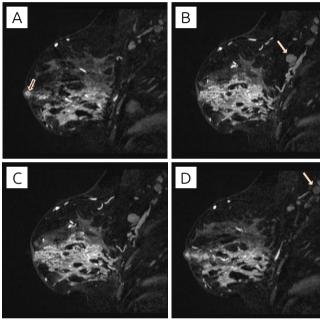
Axial magnetic resonance imaging (A) T1; (B) T2 STIR, skin edema and thickening in lateral quadrants; (C) and (D) subtraction, multiregional enhancement. Ductal ectasia.
